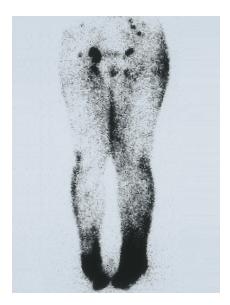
Lymphoscintigraphy of the lower limbs showing major lymph collectors and areas of dermal backflow.
